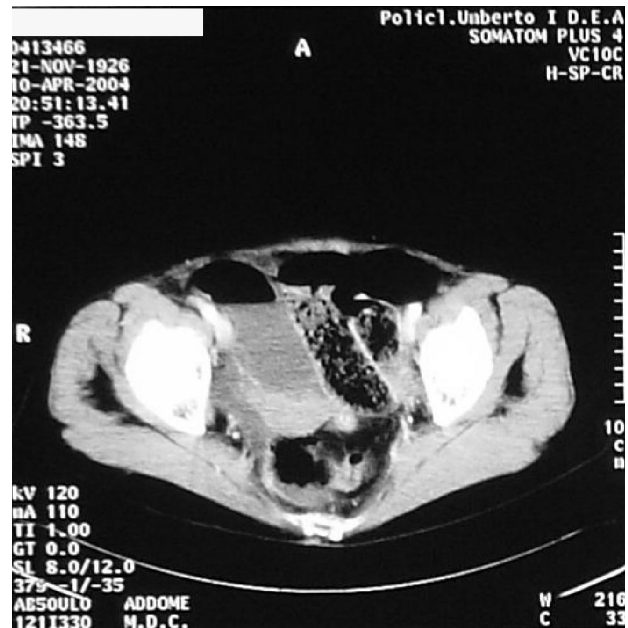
CT scan: small bowel obstruction with bowel necrosis and intramural gas.
